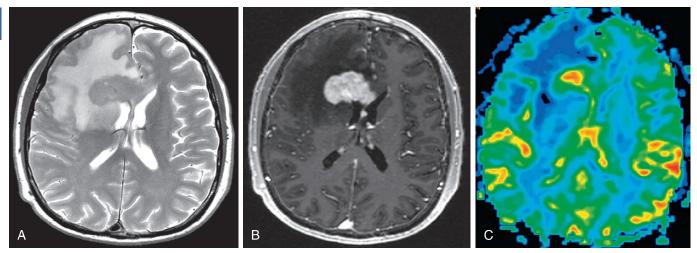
Perfusion imaging for CNS lymphoma. Brain MRI images demonstrate extensive vasogenic edema associated with a T2 hypointense (A), homogeneously enhancing callosal mass (B) with associated elevated relative cerebral blood volume (C).
